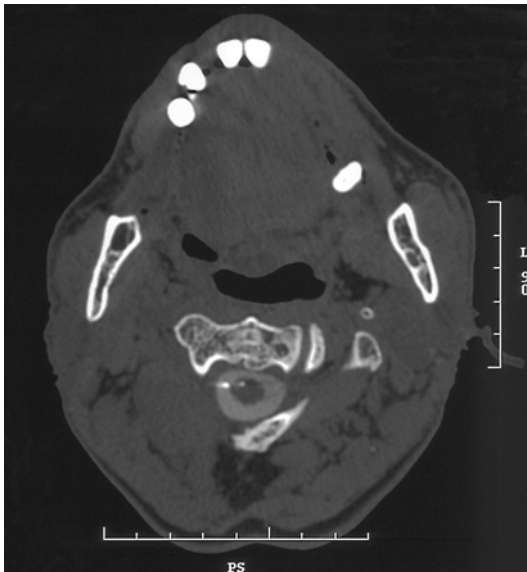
Final position of the electrode on axial CT scan at the C1–2 level in percutaneous cordotomy
